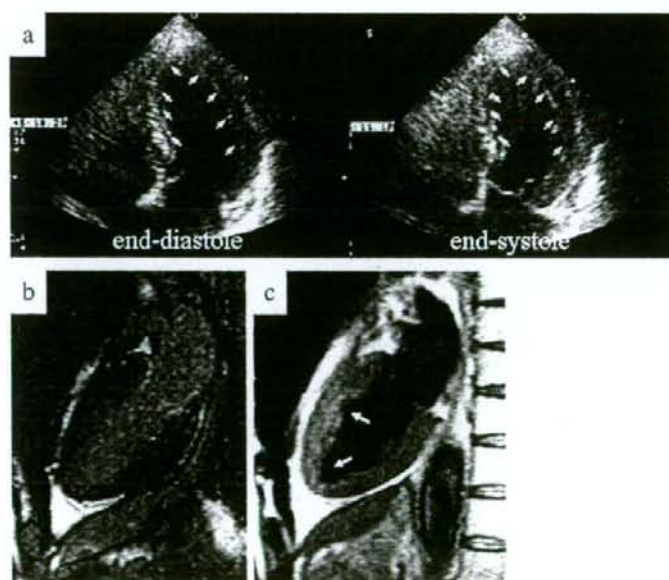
a. Arrows indicate the endocardial aspects both in the end-systolic and end-diastolic phases on transthoracic echocardiography, showing akinesis of the apical wall, which is a typical Takotsubo cardiomyopathy contractile pattern. b. No obvious late gadolinium enhancement on cardiac magnetic resonance. c. Demonstration of the transmural hyperintensity zone (arrows) in the T2-weighted image consistent with apical asynergy by transthoracic echocardiography.
